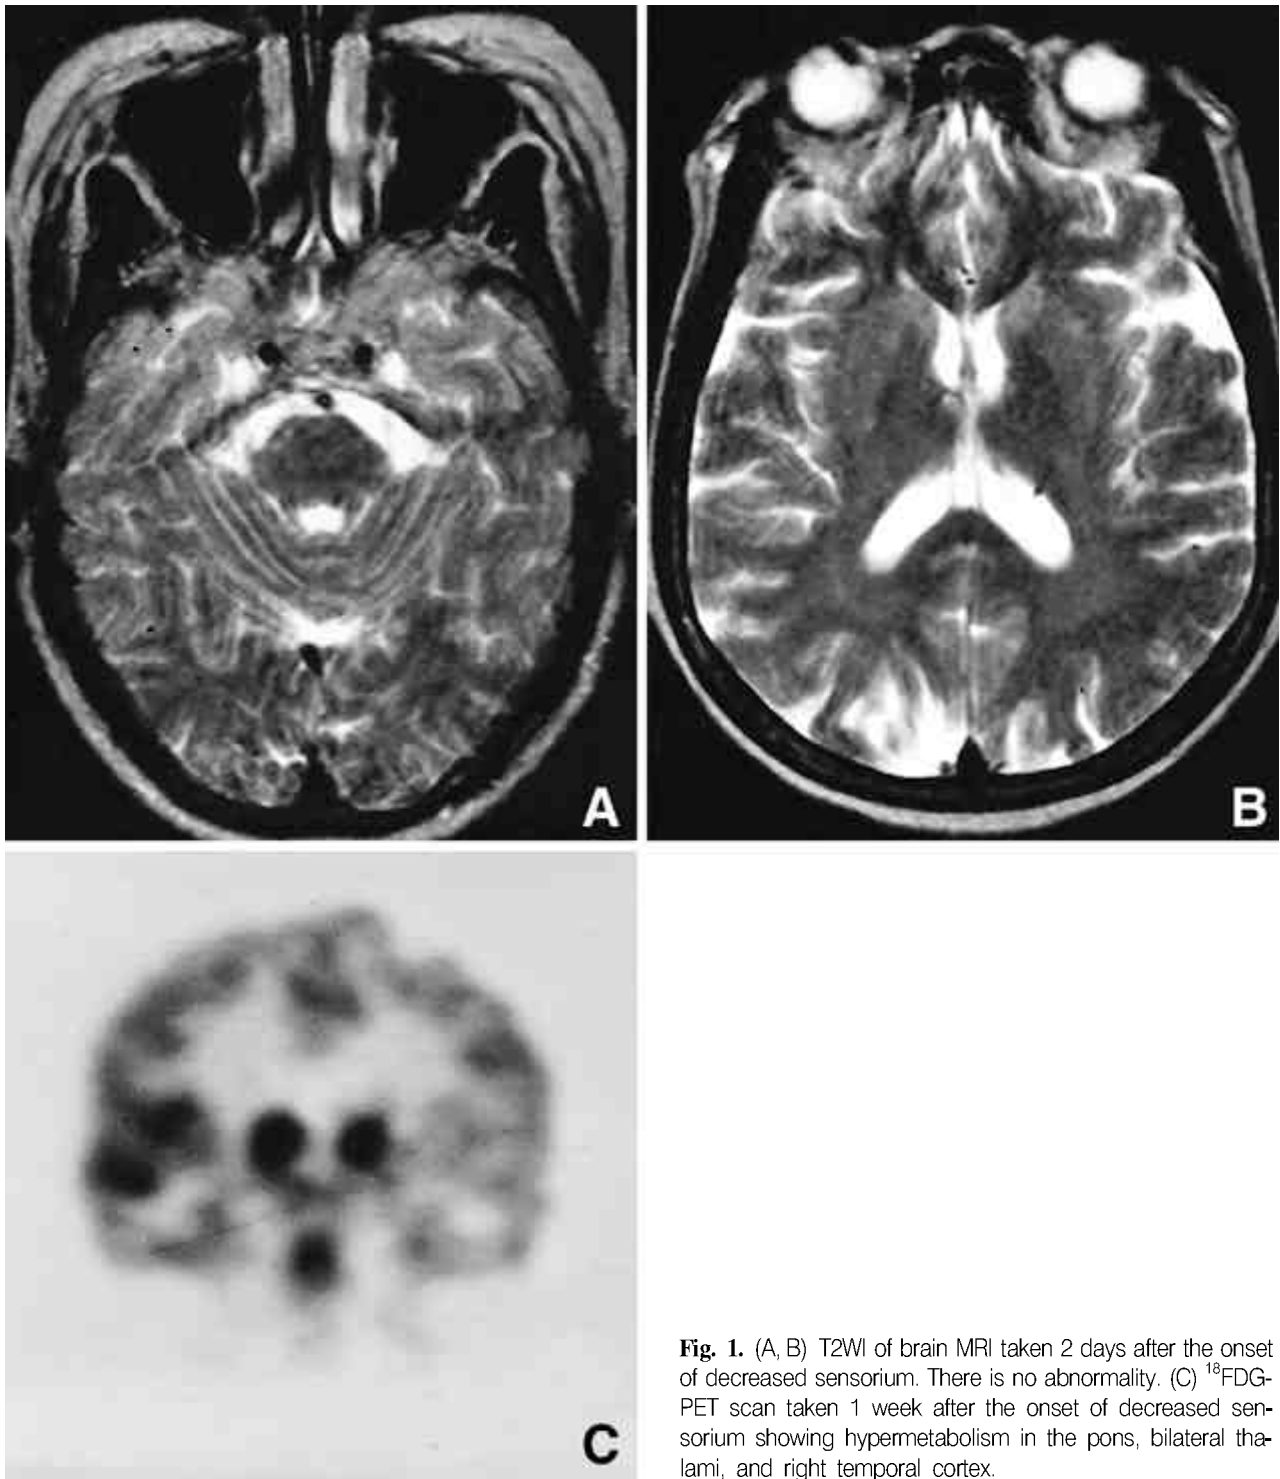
(A, B) T2WI of brain MRI taken 2 days after the onset of decreased sensorium. There is no abnormality. (C) ^{18}F FDG-PET scan taken 1 week after the onset of decreased sensorium showing hypermetabolism in the pons, bilateral thalami, and right temporal cortex.
